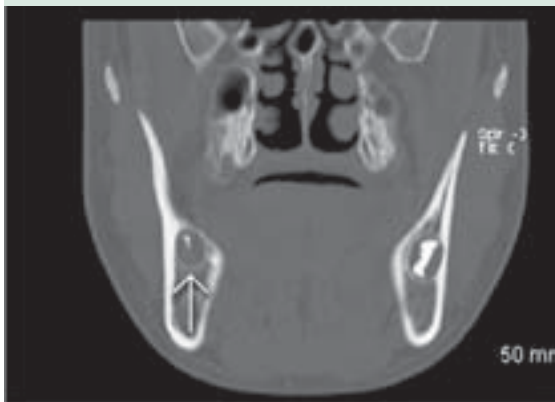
CT scan (no contrast, coronal view). Hypomineralized follicle of mandibular right third molar (arrow).
